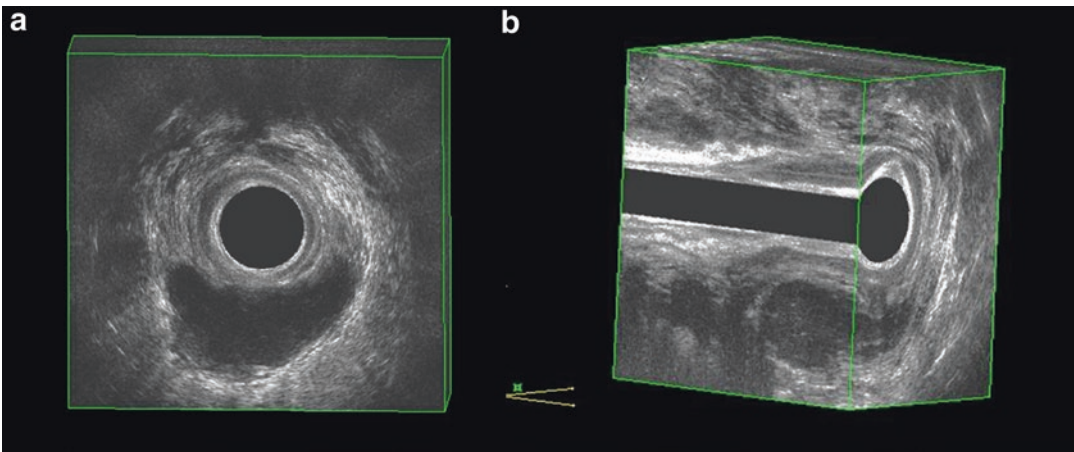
3D endoanal ultrasound with BK 2052. (a, b) Acute abscess in the posterior intersphincteric space presenting as an area of low reflectivity
